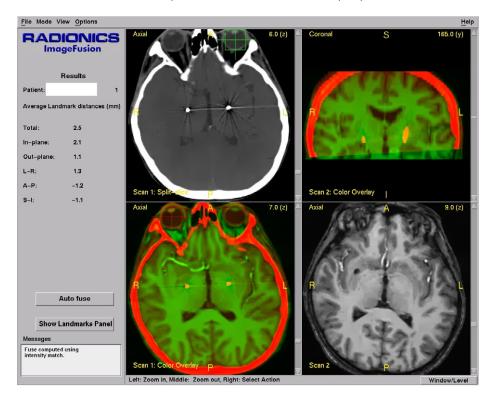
Image fusion software showing post-operative CT scan fused with the pre-operative MRI scan. Electrodes are in the medial pallidum bilaterally.
